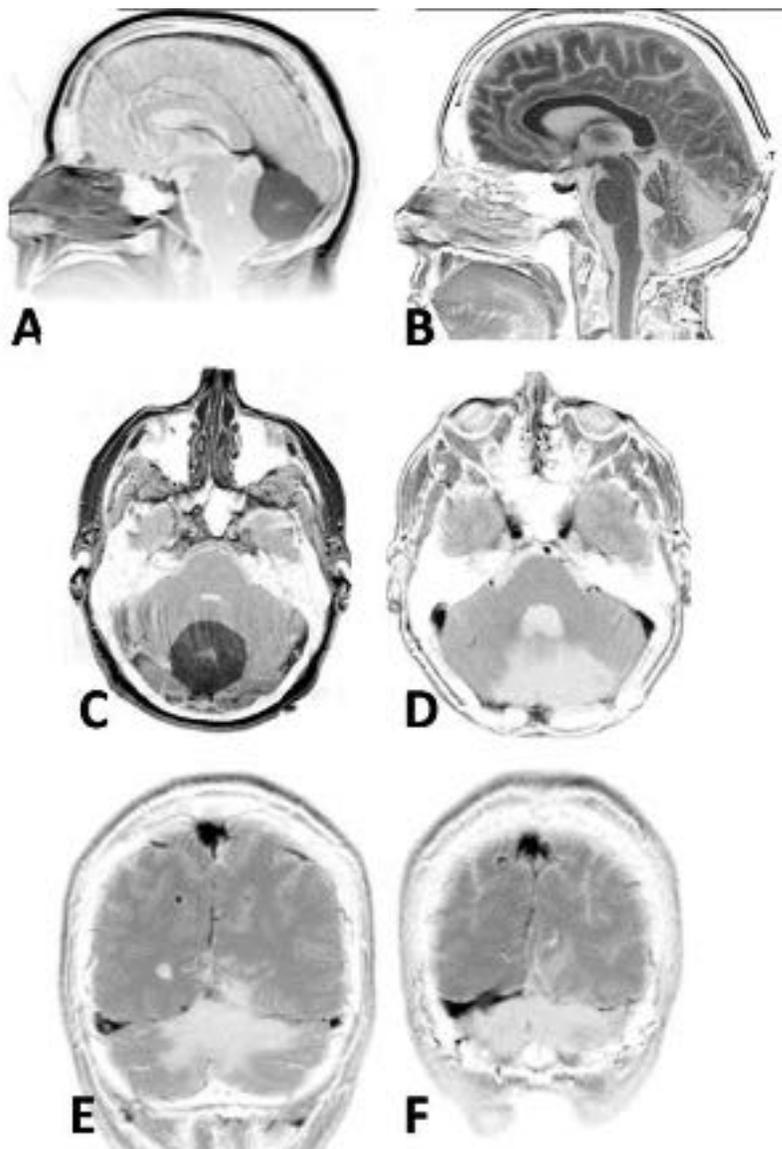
Torcular-tentorial meningioma. A 56-year-old woman presented with headache and ataxia. This large meningioma arising from the torcular and tentorium along the straight sinus [T1-weighted magnetic resonance imaging (MRI) with gadolinium in (A) sagittal and (C) axial planes] was completely removed with the exception of a small plaque along the junction of the torcular and right transverse sinus (E). Follow-up over 9 years has shown no recurrence—T1-weighted sagittal without gadolinium (B), and axial (D), and coronal (E,F) MRI, with gadolinium.
